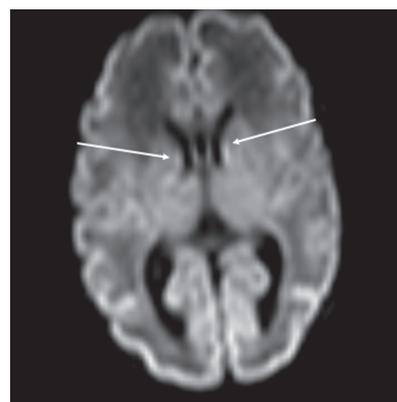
MRI of preterm newborn (PCA 30 wks.), DWI, axial plane. The germinal matrix is visualized along the external walls of the lateral ventricles (marked by arrows)
